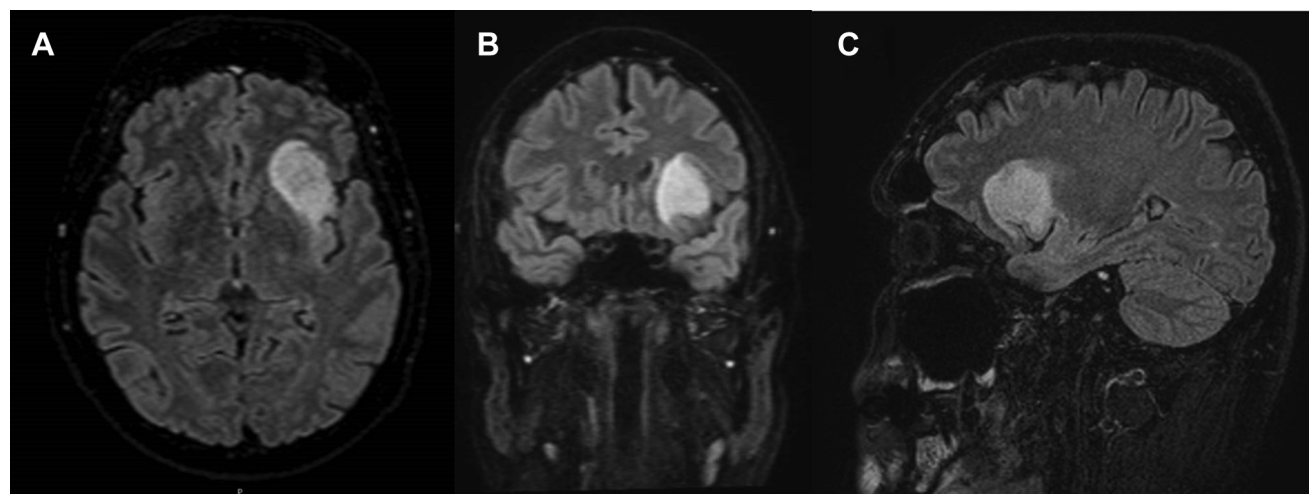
Case 1. Preoperative axial (A), coronal (B), and sagittal (C) T2 fluid-attenuated inversion recovery magnetic resonance imaging
